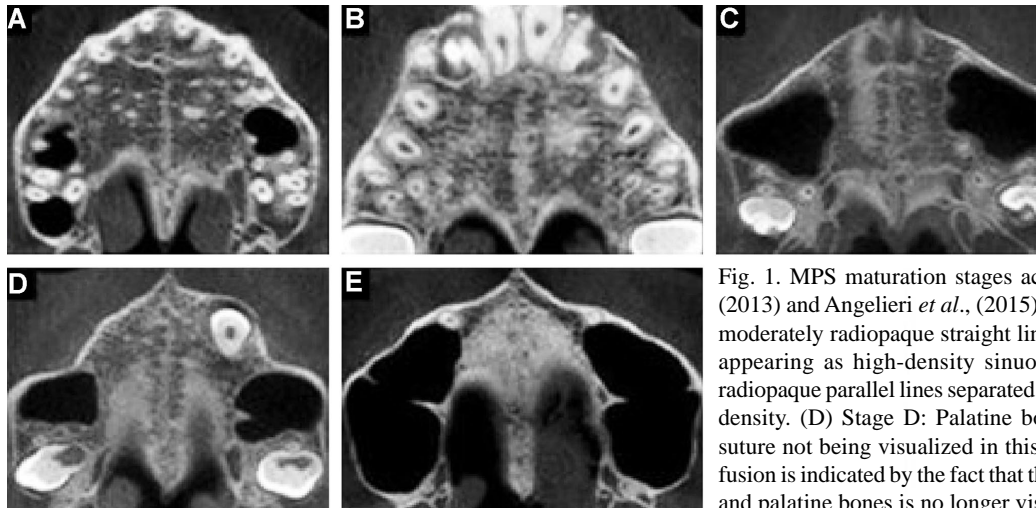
MPS maturation stages according to Angelieri *et al.*, (2013) and Angelieri *et al.*, (2015). A) Stage A: MPS seen as a moderately radiopaque straight line. (B) Stage B: MPS suture appearing as high-density sinuous line. (C) Stage C: Two radiopaque parallel lines separated by areas of low radiographic density. (D) Stage D: Palatine bones more radiopaque with suture not being visualized in this region. (E) Stage E: suture fusion is indicated by the fact that the suture along the maxillary and palatine bones is no longer visible. stage E.
